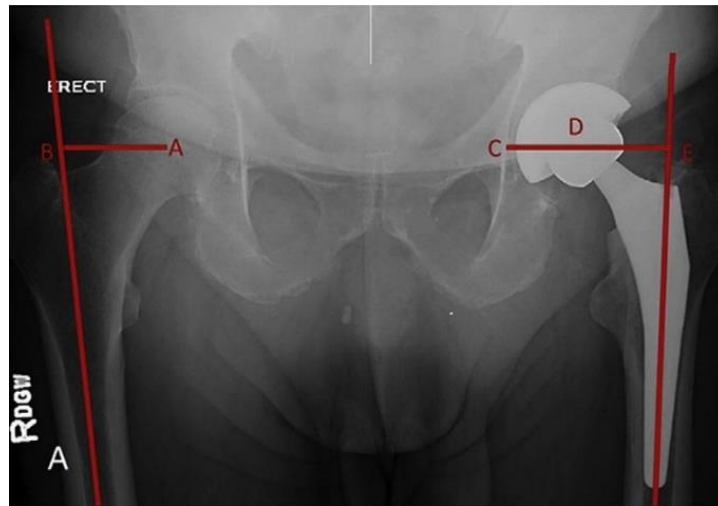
Radiographic measurements of the offset. BA: femoral offset. CD: acetabular offset. CDE: global offset ⁽²³⁾.
